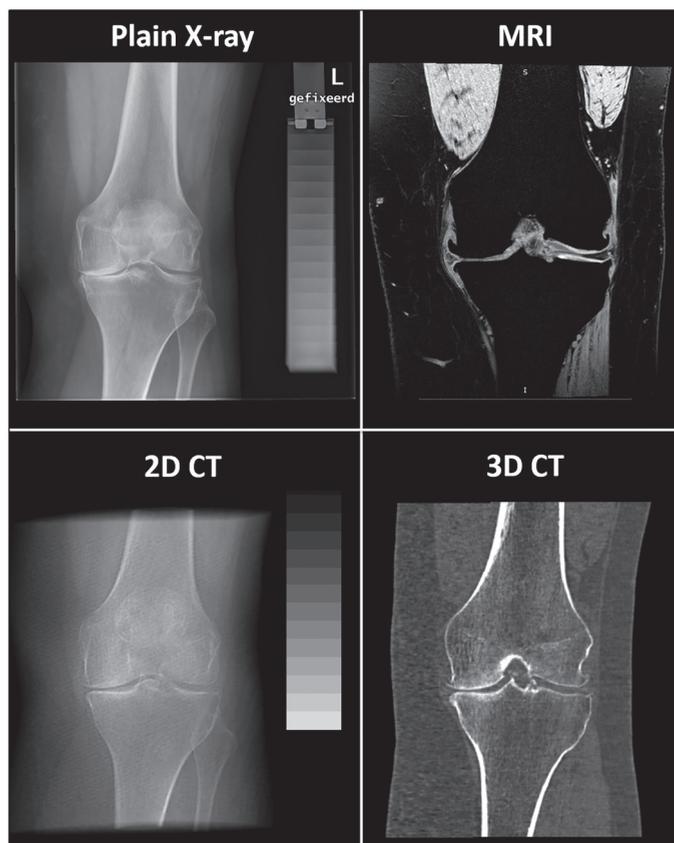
Representative image of the 4 techniques that are compared; all images are taken from the same patient before treatment (baseline). For MRI and 3D CT 1 slice is shown, since they are 3D imaging techniques. The 2D CT images is created by over-projecting the CT scan, after standardized positioning, in the coronal plane.
